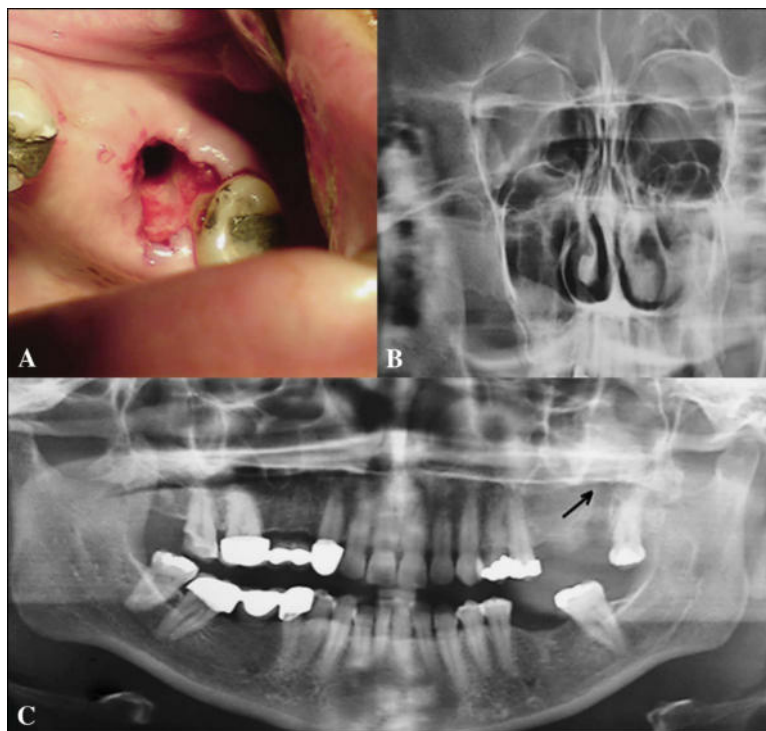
A, Intraoral appearance of OAC at the site of the extracted tooth 27; B, the coronal view shows pathosis of the right maxillary sinus and the presence of mucocoele in the left maxillary sinus; C, panoramic radiography shows the extent of OAC (arrow).
